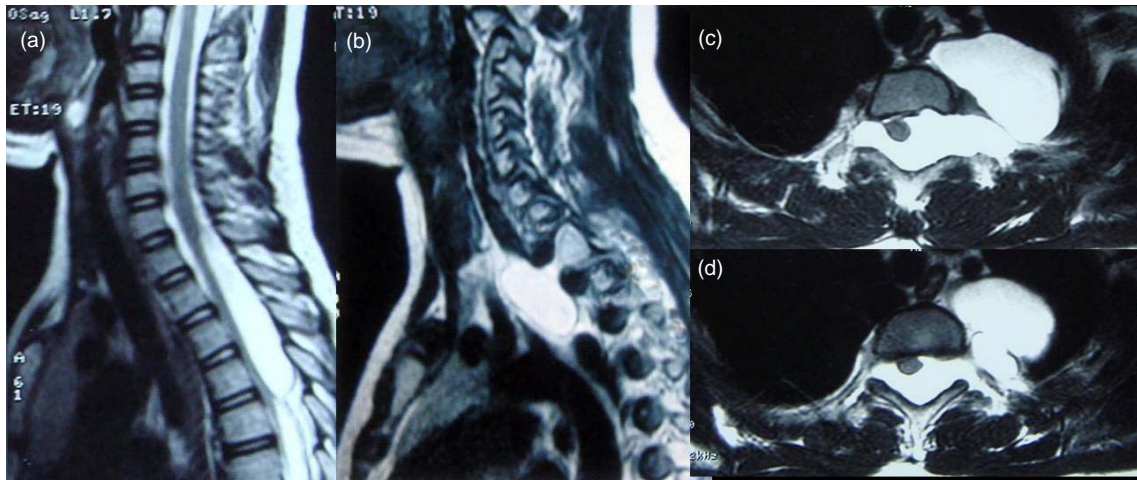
Preoperative T2-weighted magnetic resonance images: (a) Sagittal image shows that the spinal arachnoid cyst extends from T1 to T5 vertebrae and compresses the spinal cord; (b) Sagittal image shows the intrathoracic meningocele at the level of T1; (c) & (d) Axial images show that the meningocele extends into the left hemithorax through an enlarged intervertebral foramen and the spinal arachnoid cyst protrudes into the meningocele pouch
